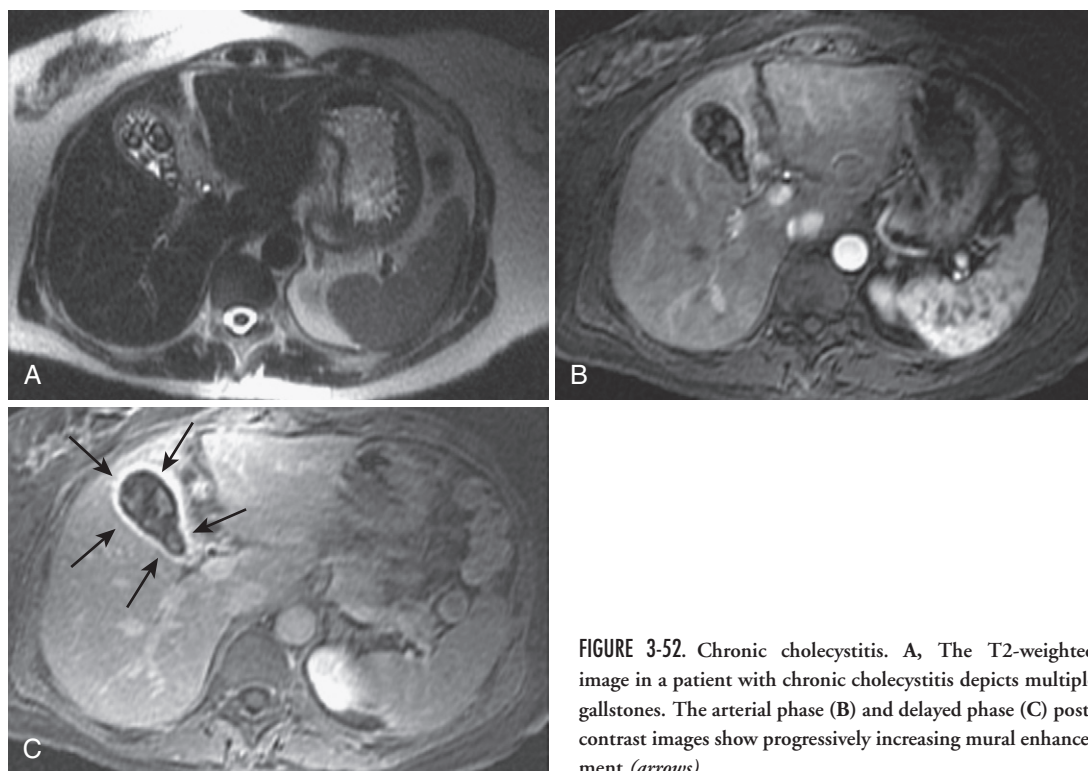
Chronic cholecystitis. A, The T2-weighted image in a patient with chronic cholecystitis depicts multiple gallstones. The arterial phase (B) and delayed phase (C) post-contrast images show progressively increasing mural enhancement (*arrows*).
